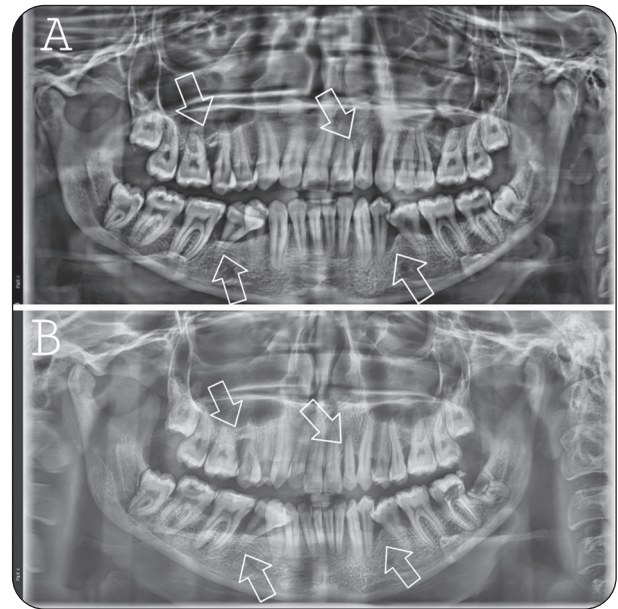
Panoramic Radiographic comparison of two periodontitis treatments: PRP (a) and ND YAG Laser (b). The upper half showcases the baseline state at day 0, while the lower half reveals new bone formation after 6 months.
